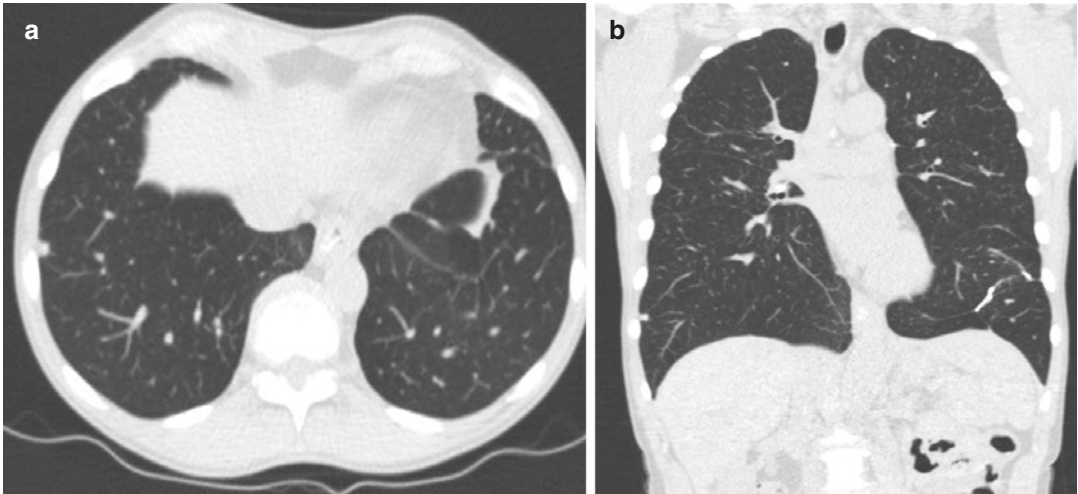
Transverse (a) and coronal (b) images of a 64-year-old man (49 kg) who underwent low-dose, non-contrast-enhanced chest CT (CTDIvol 1 mGy, DLP 44 mGy.cm) for lung nodule follow-up. There is a 5 mm subpleural nodule in the right lower lobe
